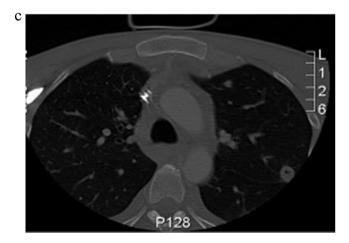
(A) CT scan in sagittal view of the neck after incision and drainage. (B) CT scan in transverse view of the neck after incision and drainage. (C) CT scan in transverse view of the chest. Lesion appreciated left lobe.
